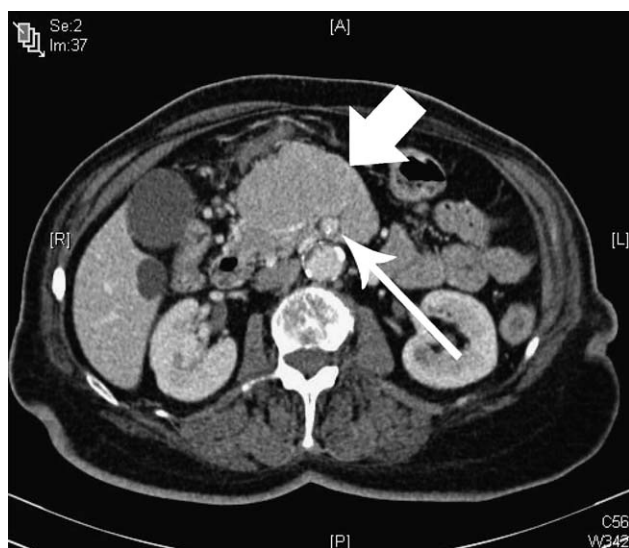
CT scan showing a large neuroendocrine tumor (*arrow*) compressing the superior mesenteric vein (*small arrow*).
